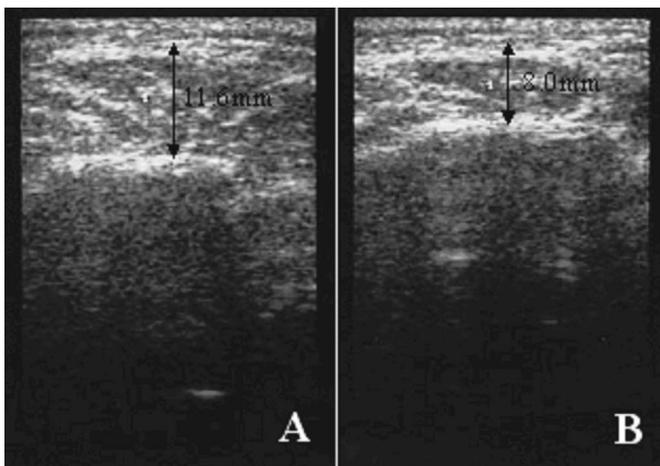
Ultrasonographic findings of measured masseter muscle, which was performed before treatment (A) and 3 months after treatment (B).
